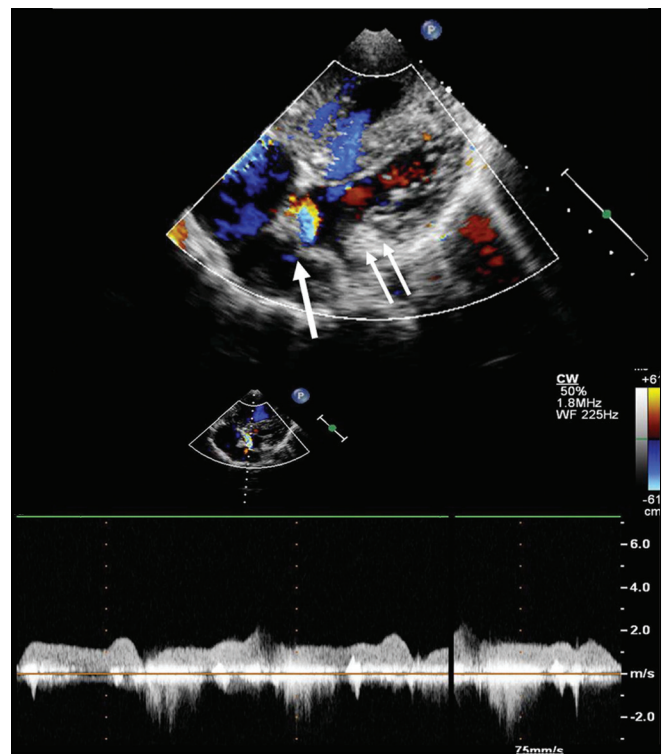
Apical four chamber view showing divided left atrium (arrow) and mitral valve leaflet (two arrows). Continuous wave Doppler across the membrane shows a diastolic gradient
